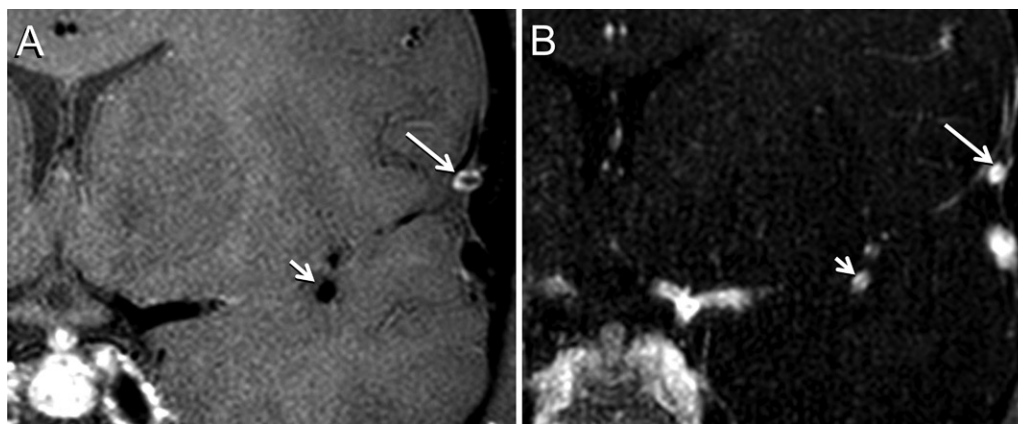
Venous enhancement mimicking vasculitis in a 31-year-old woman with a history of left-sided neck pain. Concentric wall enhancement shown on vessel wall MRI scan can be seen in a normal cortical vein (long arrow in A) and on a venous phase contrast-enhanced MR angiographic image (long arrow in B), whereas no wall enhancement is expected in the arterial wall (short arrow, M2 segment of left middle cerebral artery) under normal conditions.
